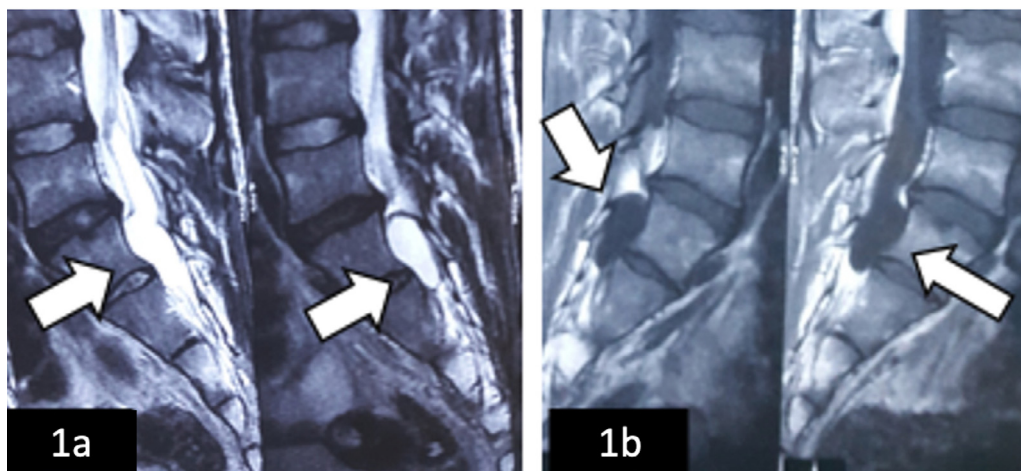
Lumbosacral sagittal MRI, (a) T2 weighted image showing a hyperintense mass at the caudal part of lumbar spine; (b) T1 weighted image with hypointense mass compatible with cystic mass (white arrows).
